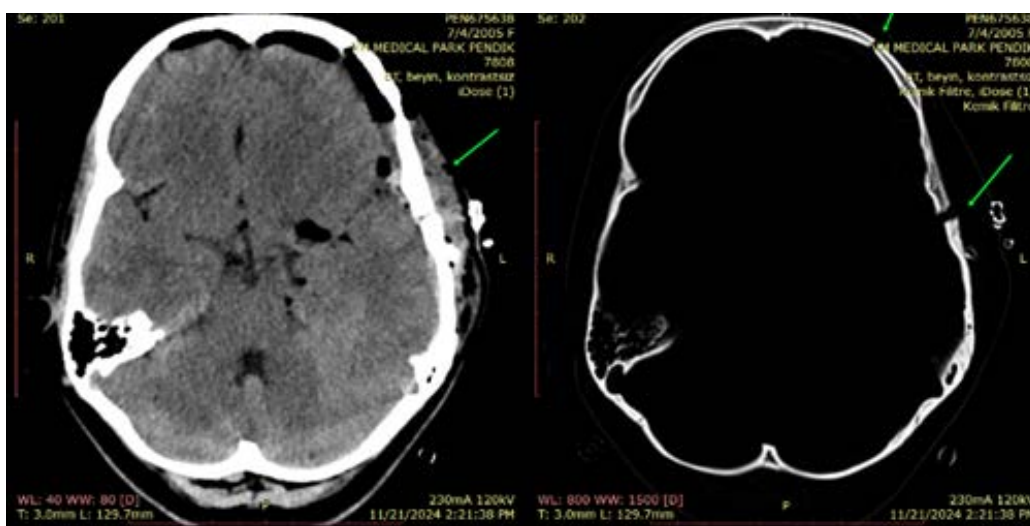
A 19-year old female with epidermoid cyst. FINDINGS: Axial non-enhanced CT of the brain demonstrates postoperative pneumocephalus and craniotomy, TECHNIQUE: Axial CT, 230mA, 120kV, 3 mm slice thickness.
